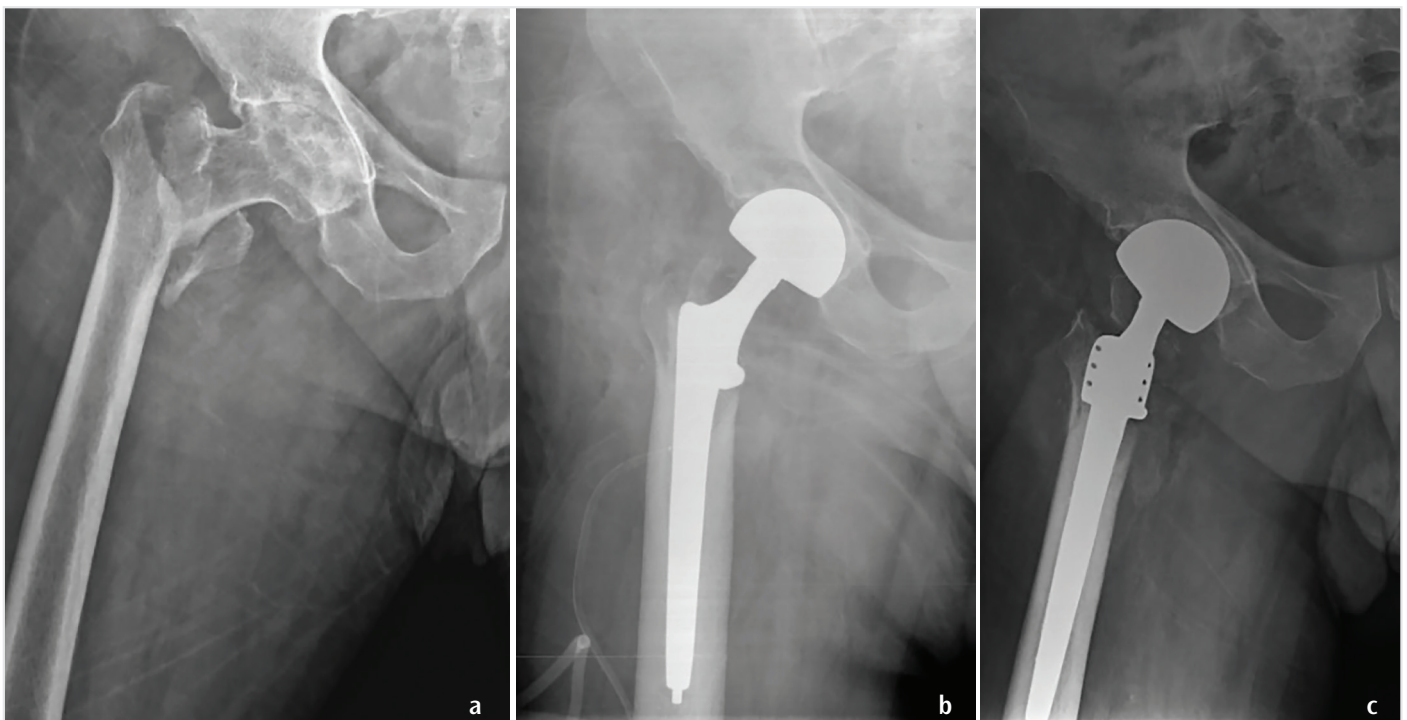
A 78-year-old male patient with an unstable intertrochanteric fracture of the right hip. Preoperative anteroposterior radiograph a) immediate postoperative radiograph following cementless hemiarthroplasty using a calcar replacement stem b), and radiograph at 1-year postoperative follow-up c). Consent of the patient is taken
